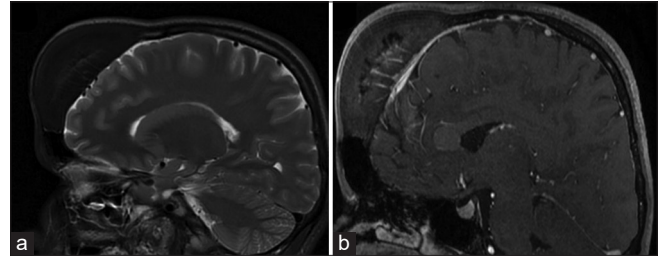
(a) Magnetic resonance imaging T2 sagittal and (b) T1 contrast sagittal.
